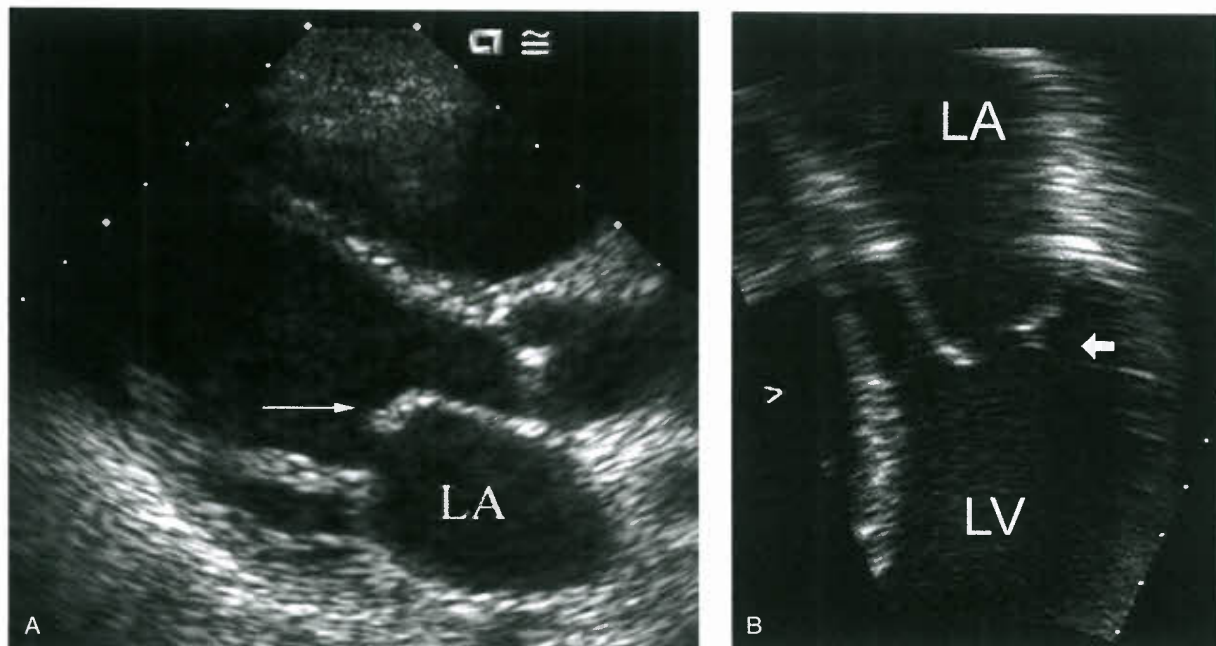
Chronic rheumatic mitral stenosis. A: Two-dimensional echocardiographic parasternal long-axis image demonstrating bent-knee or hockey-stick configuration to thickened anterior mitral valve leaflet (arrow). B: Apical four-chamber image showing thickened, echogenic leaflets and restricted diastolic opening (arrow); LA, left atrium; LV, left ventricle.
